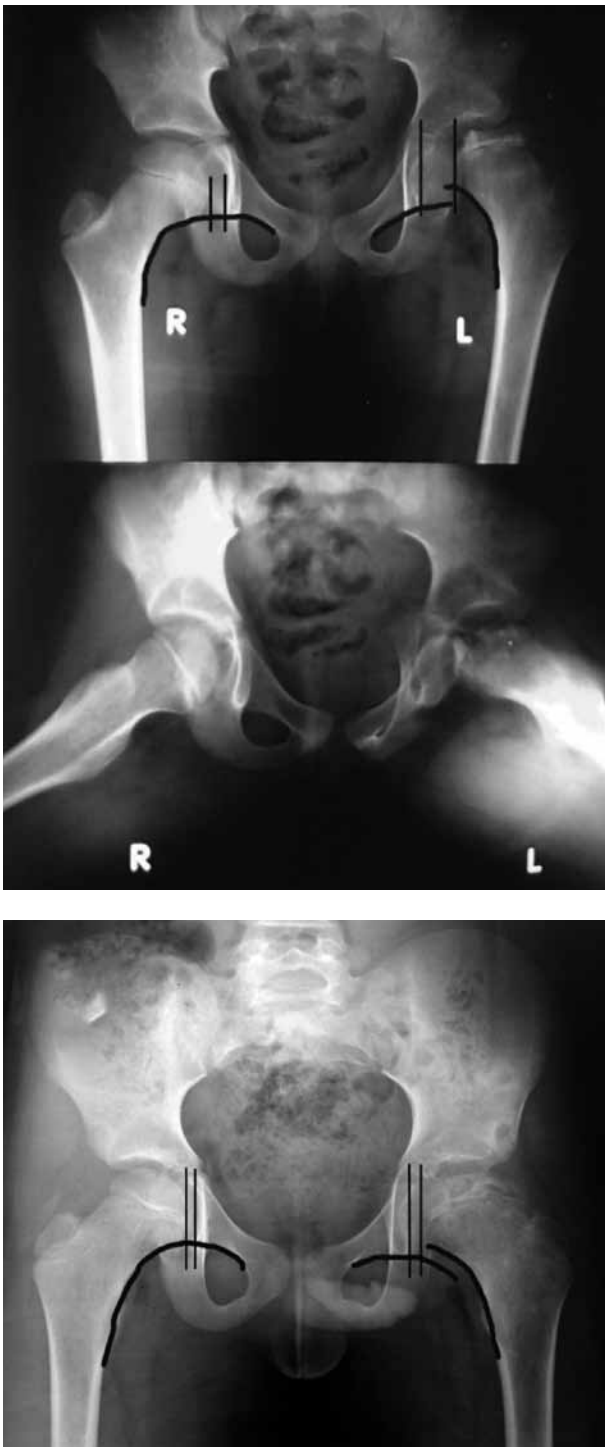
(Case 1) 8-year- old male. A : Pre-operative radiograph showing Herring class C Perthes' disease of the left hip, with 15 mm lateral subluxation and 8 mm superior subluxation. B : Follow-up radiograph after 3 years showing much improvement in lateral subluxation which reduced to 4 mm and in superior subluxation to 5 mm.
